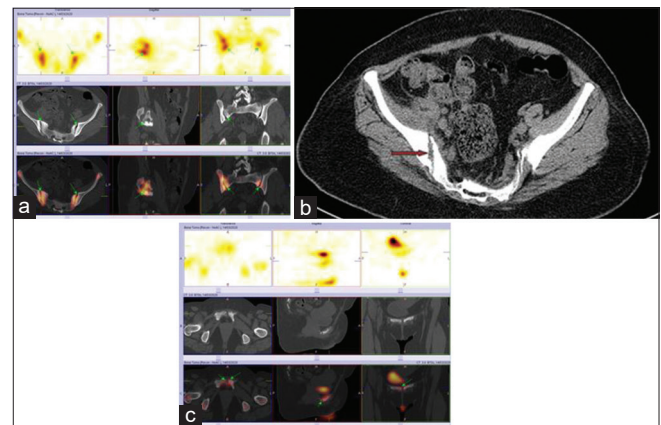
(a) Single-photon emission computed tomography with low-dose screening computed tomography of the pelvic region showing increased tracer concentration in the articular margin erosions with adjoining sclerosis in bilateral sacroiliac joints. (b) Computed tomography scan acquired with single-photon emission computed tomography for attenuation correction showing soft-tissue involvement in the right sacroiliac joint. (c) Single-photon emission computed tomography with low-dose screening computed tomography of the pelvic region showing increased tracer concentration corresponding to healed fracture in the left inferior pubic ramus
